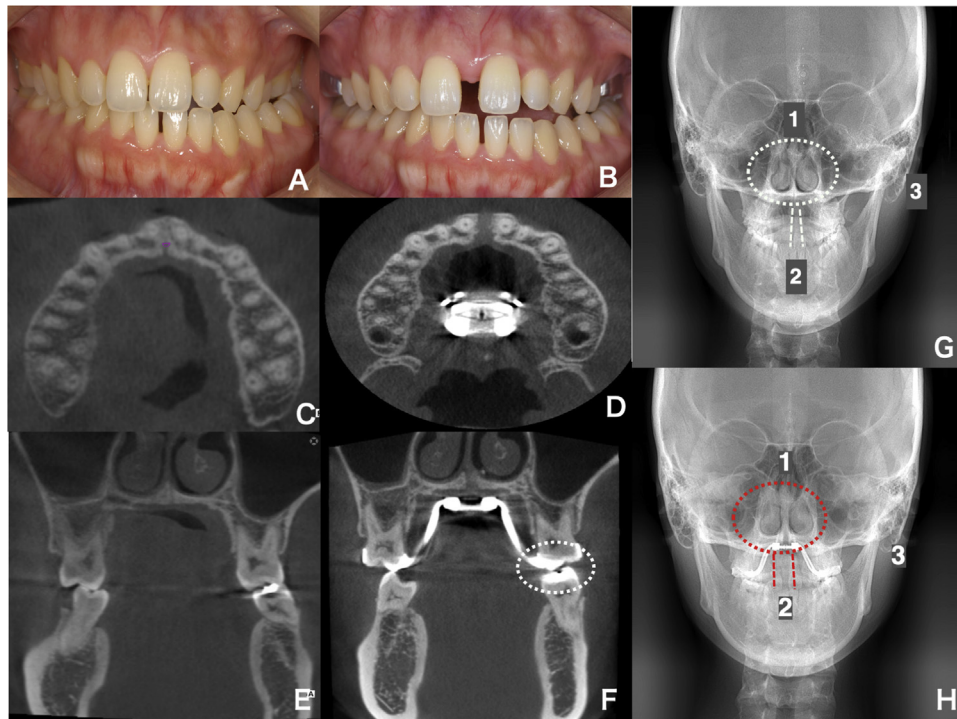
Patient 2: A and B, intraoral photographs before and after the maxillary skeletal expansion; C and D, cross-sectional CBCT images before and after expansion; E and F, sagittal CBCT view before and after expansion. Correction of the crossbite at the first molar is indicated (*white* in F); G and H, PA radiograph before and after expansion. Notice the changes in the nasal cavity (1, *dotted circle*), maxillary central incisor angulation (2, *dotted line*), and the shape of the maxilla (3).
